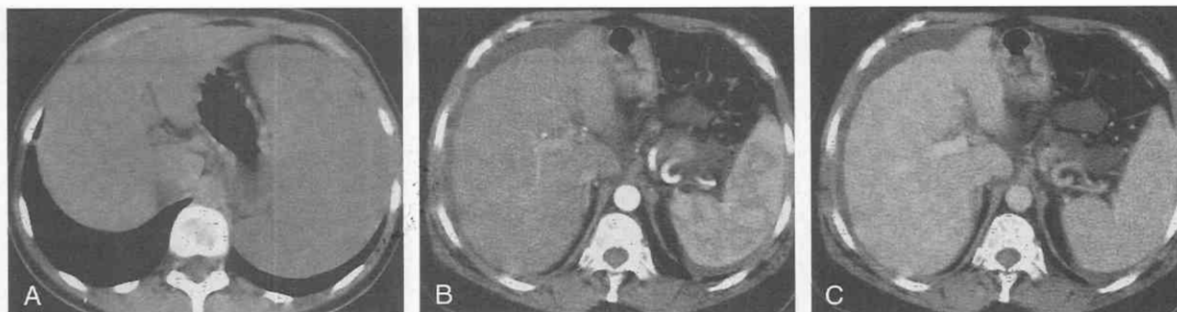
Autoimmune hepatitis in a 66-year-old woman. *A*, Unenhanced CT scan shows splenomegaly without significant reduction in signal intensity of the hepatic parenchyma. *B* and *C*, After application of contrast medium, ascites becomes more visible. As is typically the case, the liver itself appears normal.
